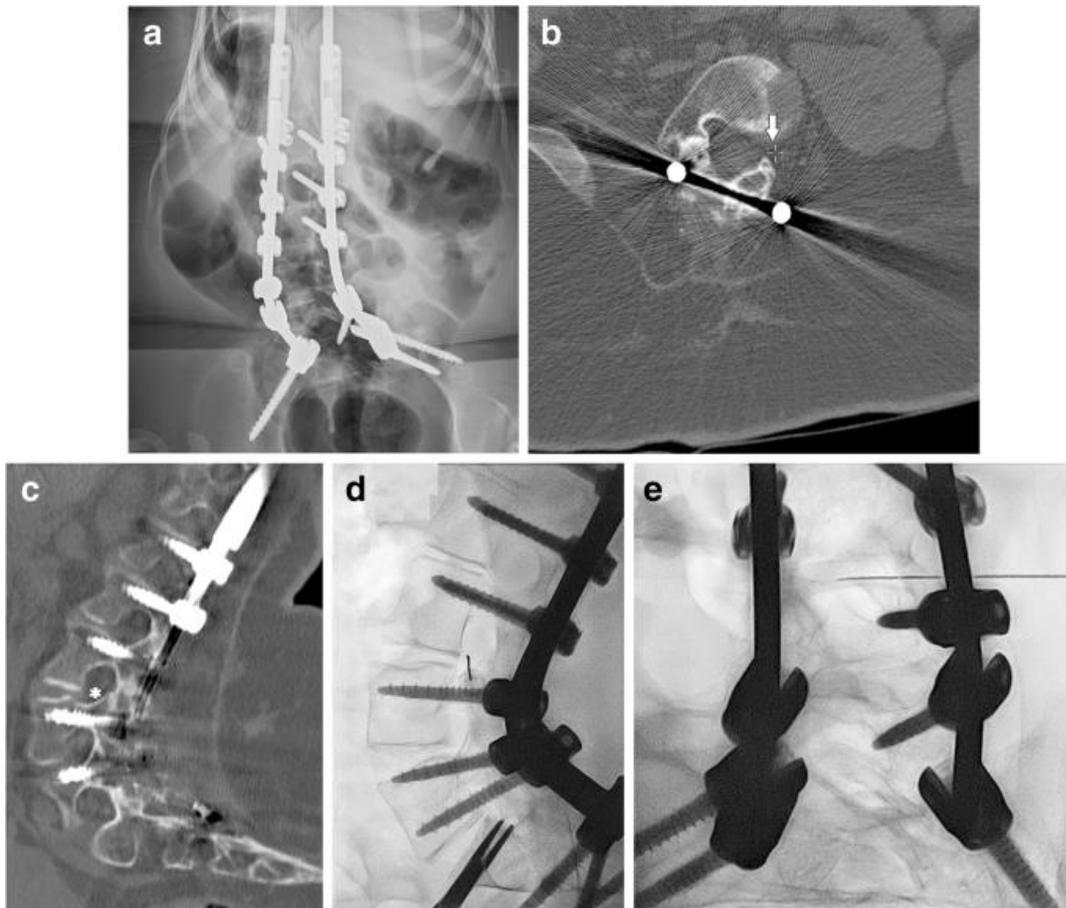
Spinal muscular atrophy type 2 post spinal fusion and rod placement in a 14-year-old girl. a Anteroposterior lumbar spine radiograph demonstrates spinal fusion hardware. b, c Axial and sagittal non-contrast lumbar spine CT images demonstrate plausible intra-thecal access via the left L3-L4 neural foramen (*arrow*). Note positioning of the in the lower half of the neural foramen (*asterisk*) to avoid injury to the neurovascular structures. d, e Lateral and anteroposterior fluoroscopic images demonstrate spinal needle traversing the lower neural foramen with tip positioned in the central canal
